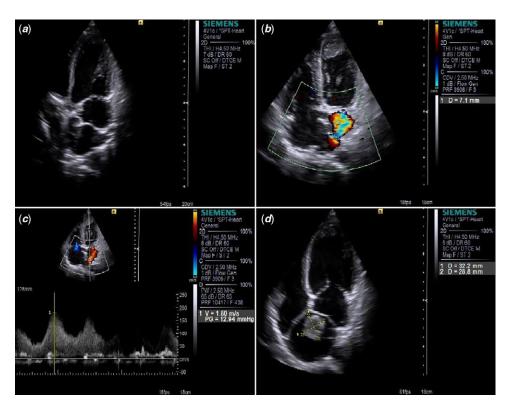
(a) Transthoracic 2-dimensional echocardiography shows a membrane-like structure traversing the left atrium. (b) Colour Doppler echocardiography shows a small communicating orifice about 7.1 mm of the membrane. (c) Colour Doppler echocardiography reveals significant flow acceleration across the membrane (estimated mean pressure gradient, 12.94 mmHg). (d) Transthoracic 2-dimensional echocardiography shows a mass in the posterosuperior chamber.
